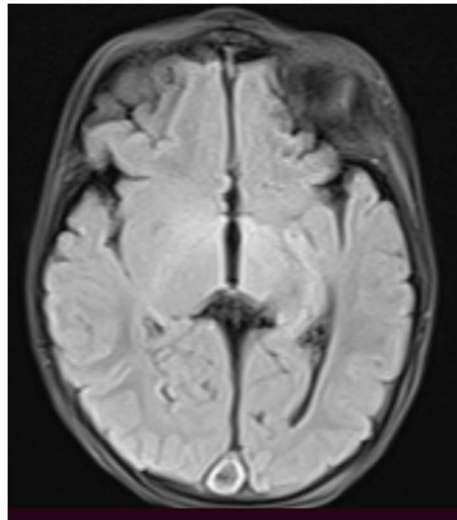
MRI Brain (Axial view): Prominent Superior Saggital Sinus
